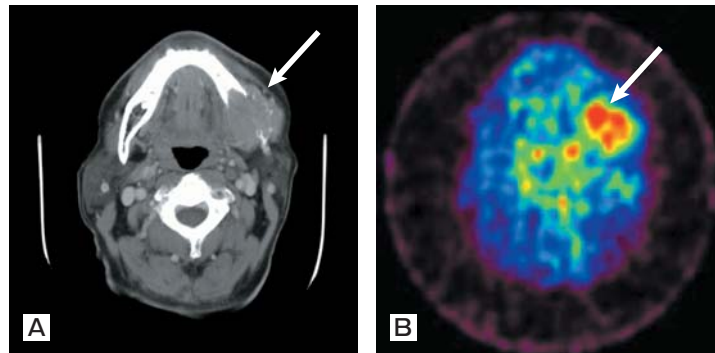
A, Computed tomography (CT) findings of the left mandible revealed an osteolytic lesion with expanding growth; B, FDG-PET showed a strong accumulation in the left mandible. The standardized uptake value (SUV) of FDG was 4.77.
